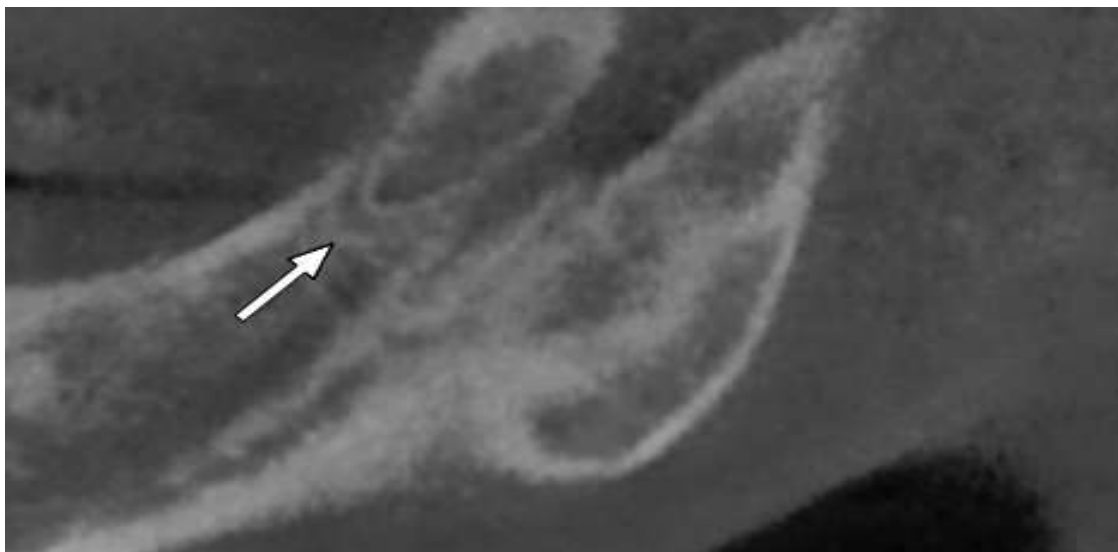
Sagittal cone-beam computed tomography image. The white arrow indicates the retromolar canal.
